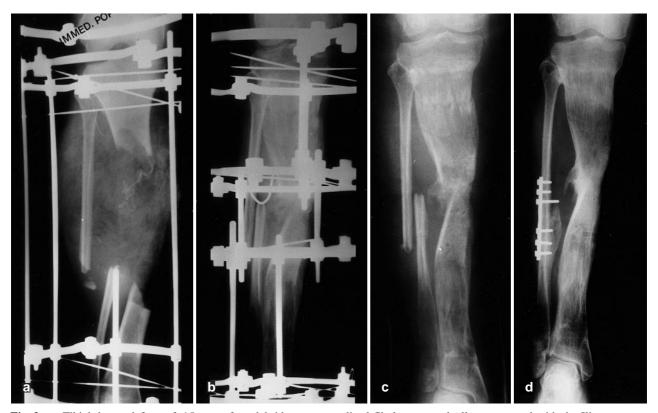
a Shortening and fibular hypertrophy due to an infected non-union of the left tibia. b Proximal tibial corticotomy and distal tibiofibular corticotomy were performed to correct the shortening and the bone defect. c Radiograph at final follow-up
